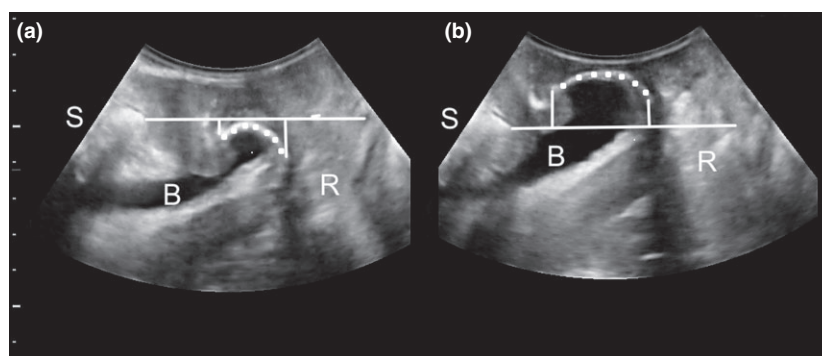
Mesh imaging on translabial ultrasound at rest (a) and on Valsalva (b). The Perigee mesh is identified by the dotted line. A hyperechoic mid-urethral sling can also be seen in this image. B, bladder; R, rectum; S, symphysis pubis. Reproduced with permission from Shek⁹.
